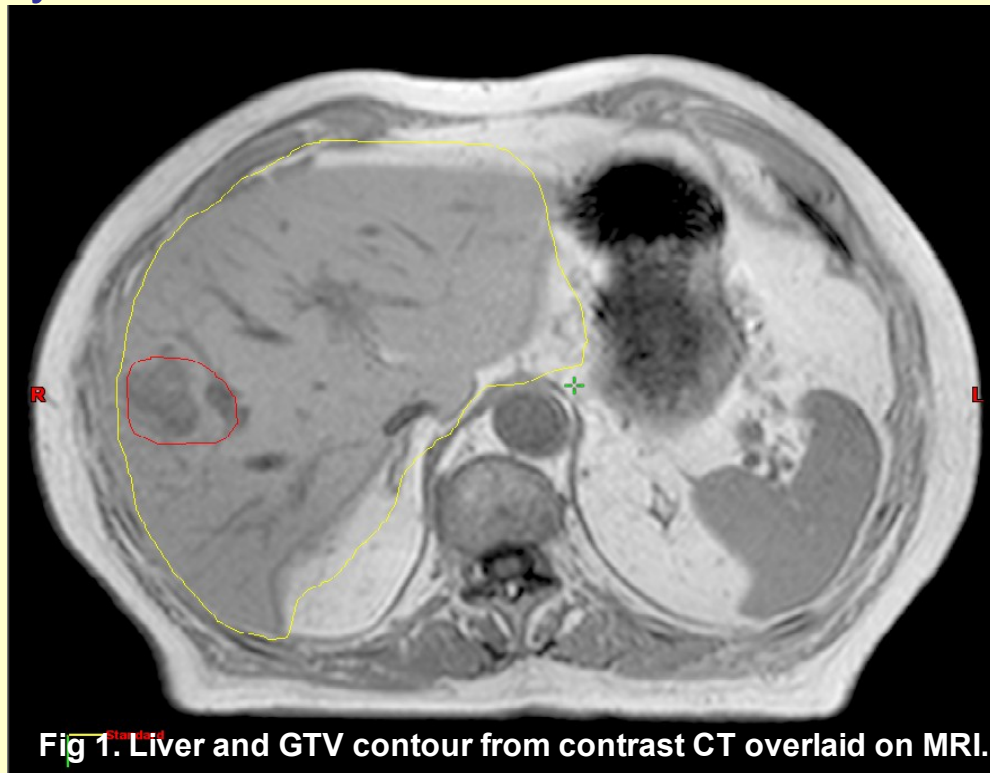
Liver and GTV contour from contrast CT overlaid on MRI.
